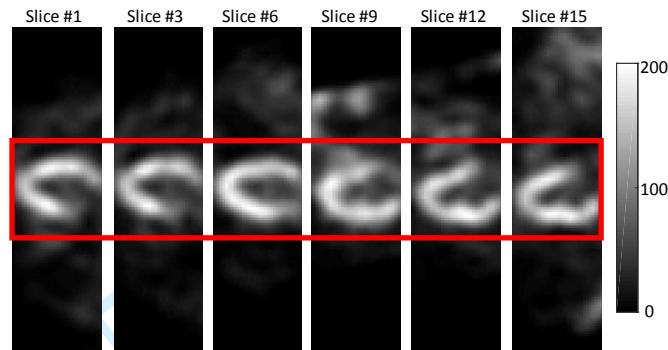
Example of SPECT heart images. From left to right it shows different slices of SPECT heart image. The display window is [0, 200].
